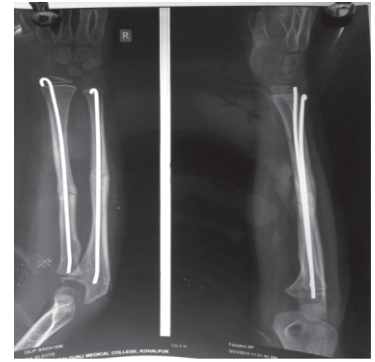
Follow up X-ray at 12 weeks
